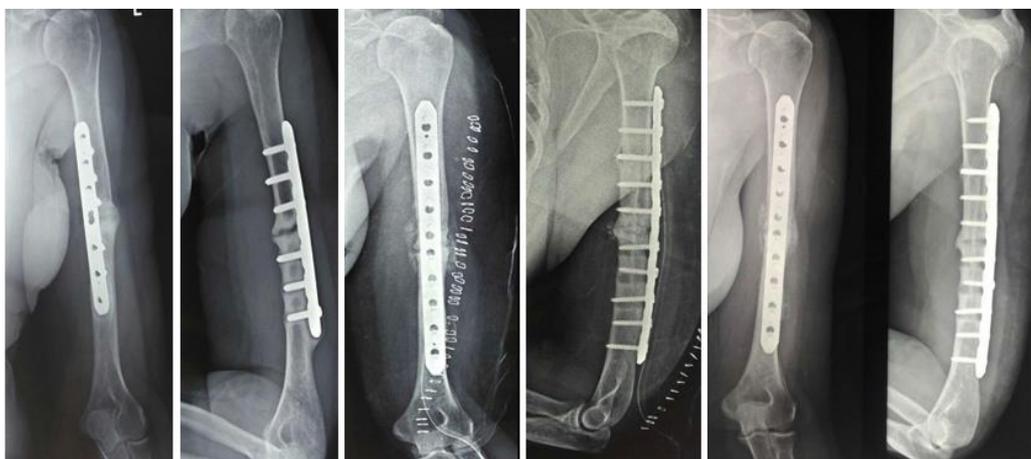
39 yr/F with Humerus plating 1and half yrs back with gap non union of 3mm a. Locking plate was removed and locking plate with non-vascularised fibular strut graft augmented with corticocancellous grafting was done. Post-operative X-ray AP/Latera Limmediate and after 3 months.
